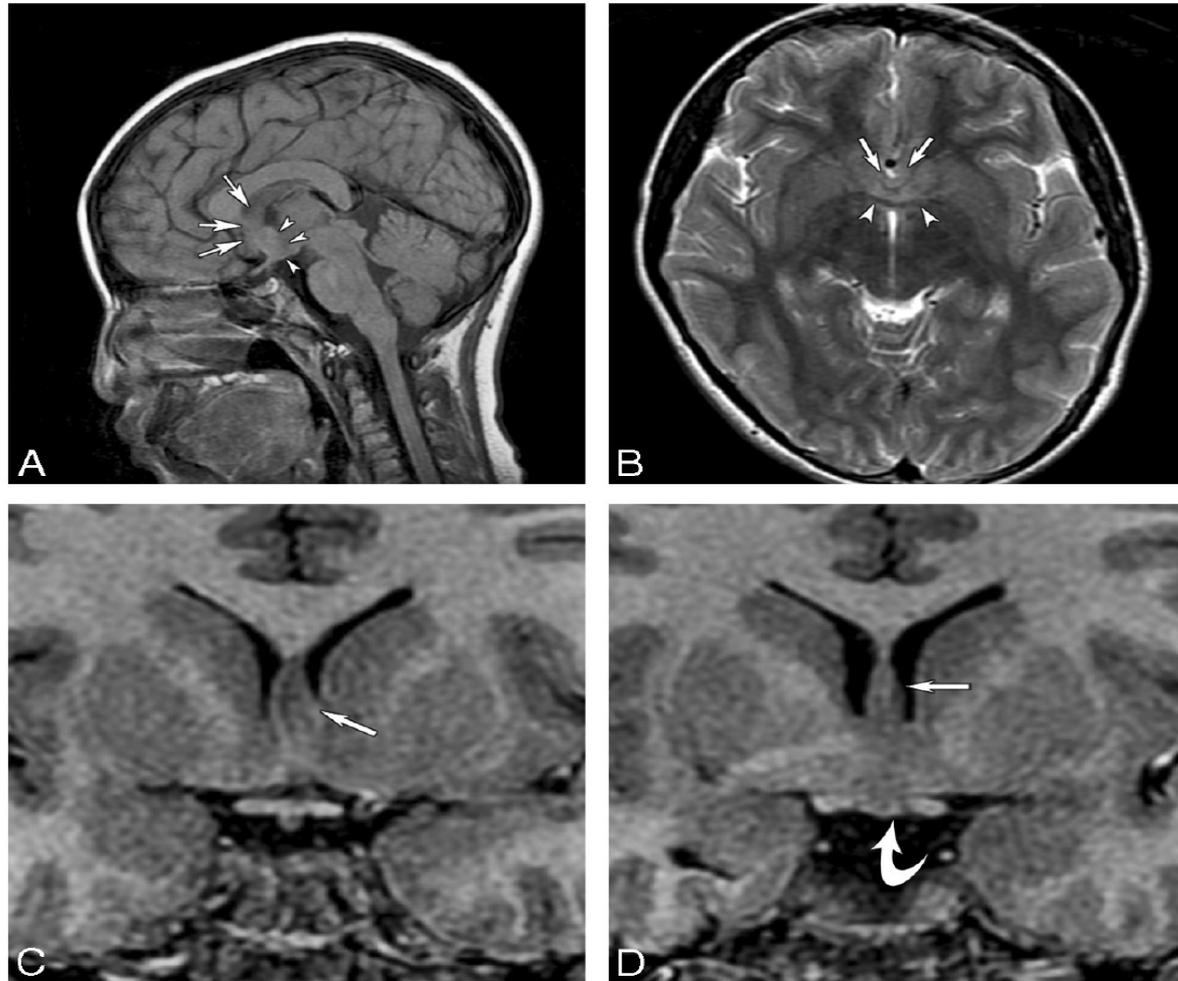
MR imaging of a 10-year-old boy with learning disabilities, a SMMCI, CNPAS, precocious puberty, and other endocrinopathies. *A*, T1-weighted midsagittal image shows hypoplasia of the rostrum of the CC and a rectangular area of abnormality in the subcallosal region, anterior to the hypothalamic region (*arrowheads*). The dysplastic-appearing fornix is anterior to this region (*arrows*). *B*, Axial T2-weighted image shows well-developed anterior and posterior interhemispheric fissures and an azygous ACA flow void in the anterior interhemispheric fissure. There is an area of midline fusion just anterior to the AC, which appears as a dark bowl-like band (*arrowheads*). Further anterior to this region are the dysplastic fornix (*arrows*) and cortical gray matter that is continuous in the middle. *C*, Coronal SPGR image anterior to the AC shows an area of fusion of the septal region (*arrow*). *D*, Coronal SPGR image at the level to the AC shows dysplastic thickened fornices (*arrow*) traveling below the SP and inferiorly an area of midline fusion in the preoptic region and basal structures (*curved arrow*).
